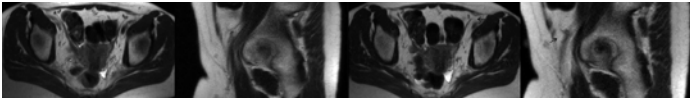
Static axial and sagittal T2-weighted MR, and dynamic axial and sagittal T2-weighted MR of occult femoral hernia not detected on CT or US. Valsalva maneuver forces a small amount of fat (*black arrows*) through the femoral triangle on the left.
